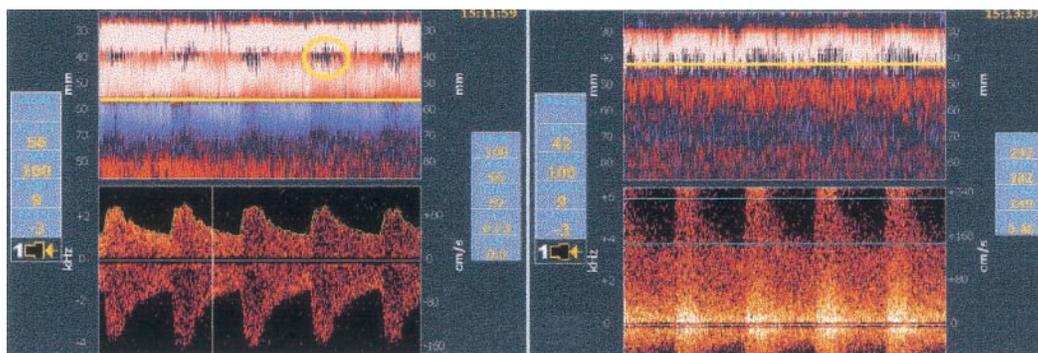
Intracranial stenosis on power motion mode Doppler (PMD) and transcranial Doppler (TCD). A 64-year-old woman with a right middle cerebral artery (MCA) stroke (National Institutes of Health Stroke Scale = 9) was admitted 10 hours after the onset of symptoms. Spectral TCD showed the mean flow velocity difference anterior cerebral artery (ACA) > MCA (left panel), indicating flow diversion to the right ACA. PMD simultaneously showed the presence of a bruit (yellow circle) at a depth of 40 mm. The transducer was repositioned over the temporal window to obtain the highest velocity signal at this location (right panel). The mean flow velocities were 66 cm/s for the proximal right MCA and 182 cm/s for the distal M1/proximal M2 segments of the right MCA, indicating severe intracranial stenosis.
